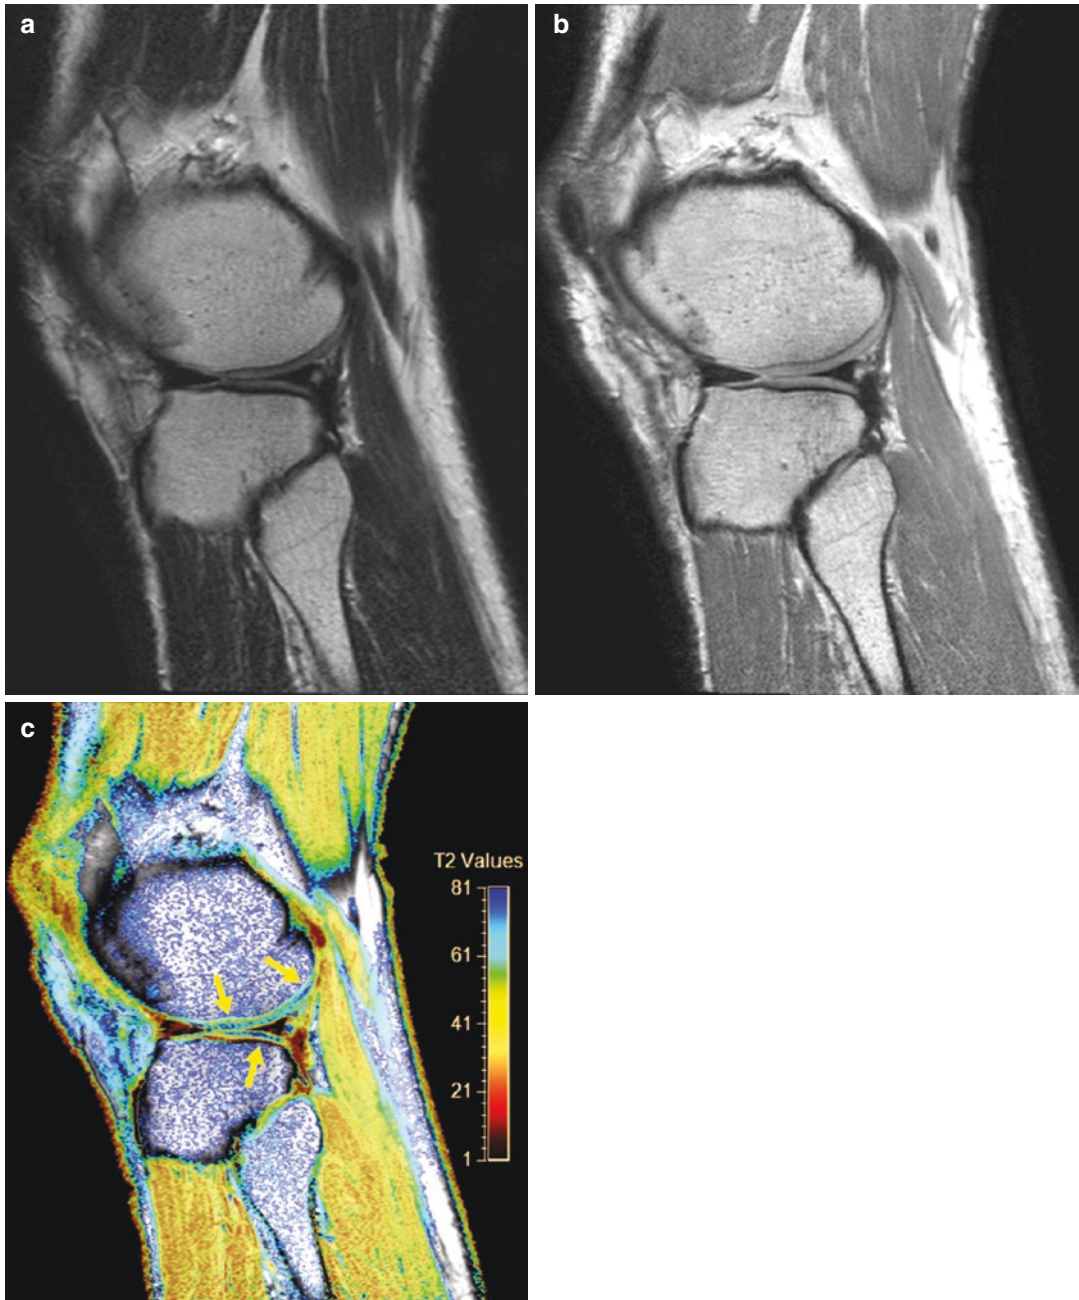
Conventional T2-weighted (a) and PD-weighted (b) MR images may show no major morphological changes in the cartilage. Color T2 mapping (c)
